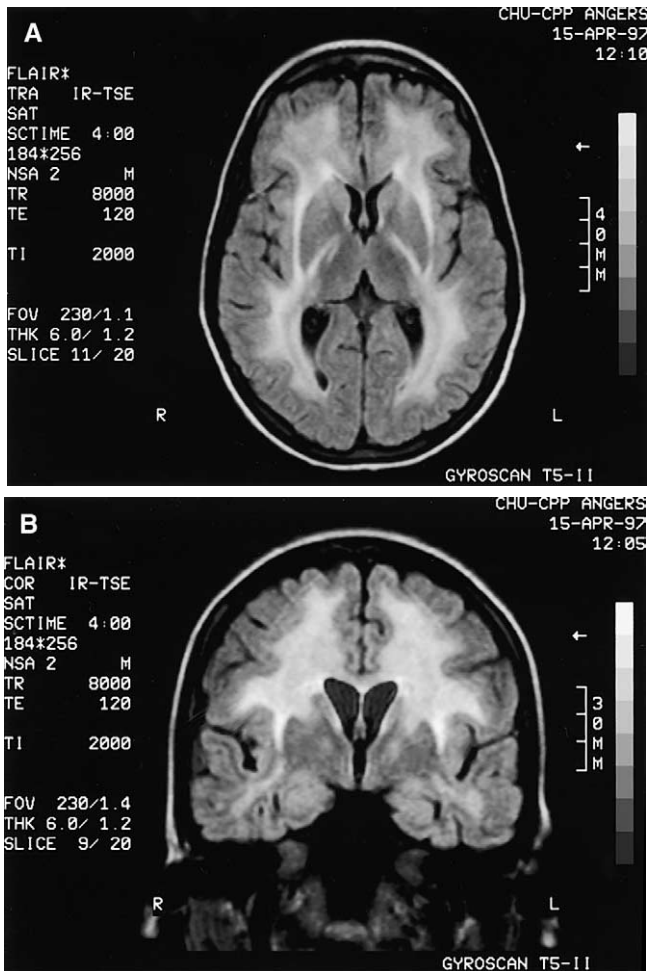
Axial (A) and Coronal (B) T2-weighted MRI of the brain showing periventricular white matter leucoencephalopathy in a patient who received high-dose methotrexate and radiation therapy for central nervous system lymphoma.
